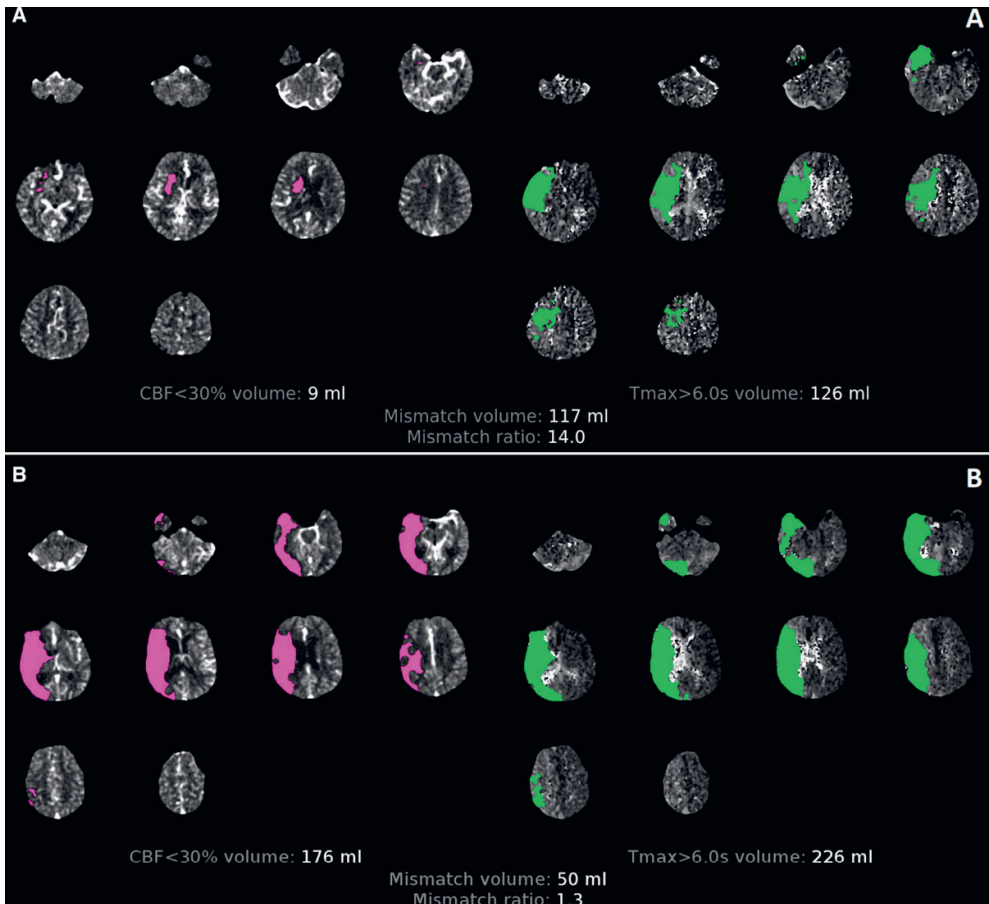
CT perfusion maps of two patients made by RAPID software, showing two different mismatch ratios. Ischaemic cores (pink) and whole perfusion deficit (green). Above (A), a patient with a high mismatch ratio (14.0), a small infarct core (9 ml) and a large mismatch volume, penumbra (117 ml). Below (B), a patient with a small mismatch ratio (1.3) and a large ischaemic core (176 ml) which largely overlaps the perfusion deficit, and with a low mismatch volume, penumbra (50 ml). Patient A is optimal for interventions. Adapted from Demeestere et al. (Demeestere, Wouters, Christensen, Lemmens, & Lansberg, 2020).
